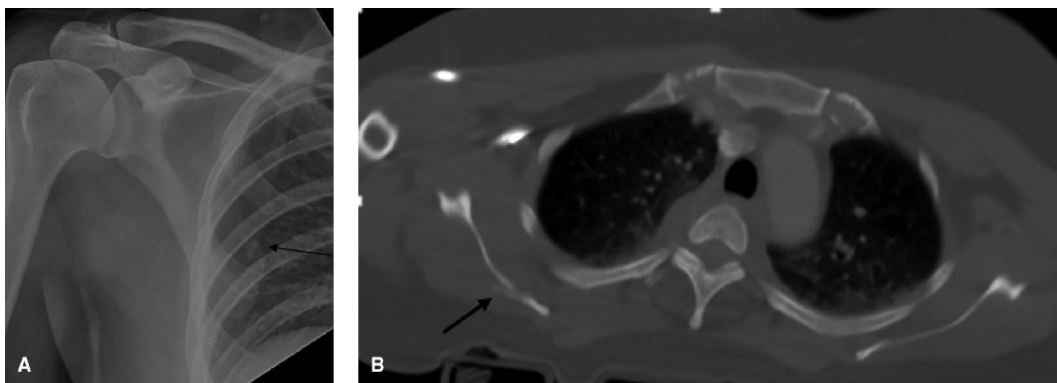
Suboptimal technique and overlying structures resulted in a missed diagnosis of a medial scapular body fracture (*arrows*). This injury was recognized on subsequent CT scan as part of a trauma protocol.
